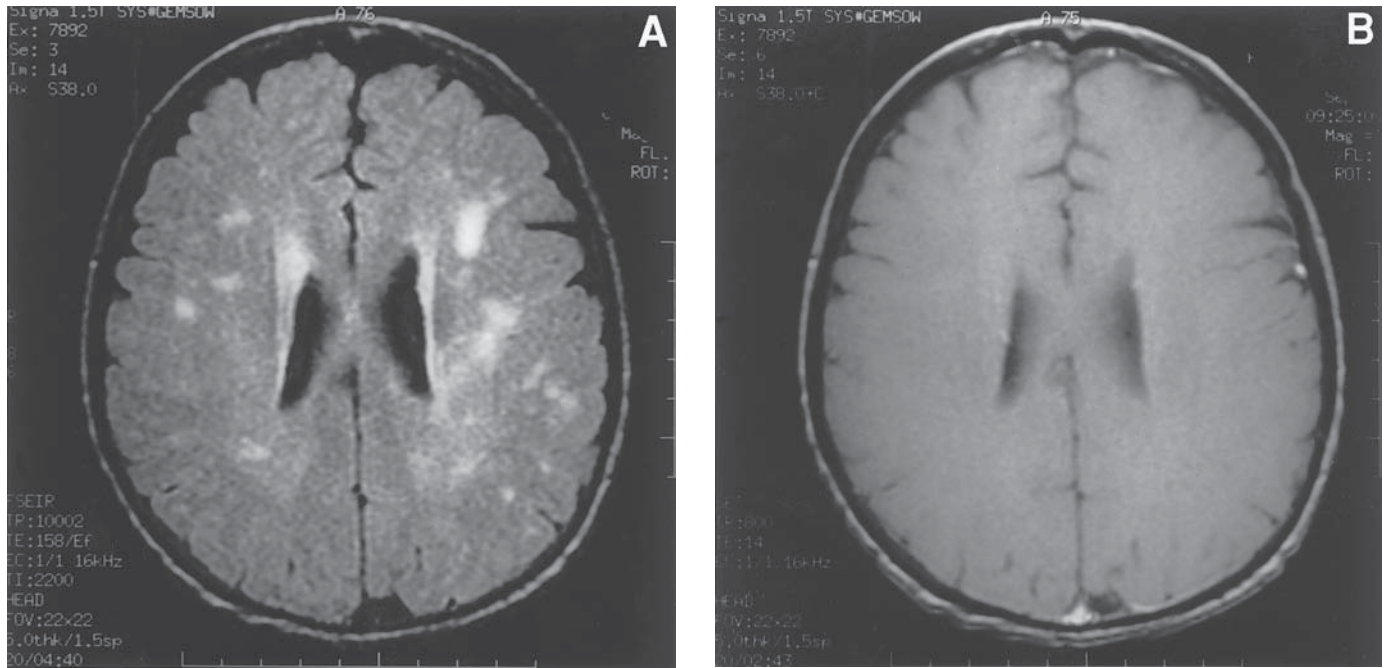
Nonspecific multiple small high-intensity lesions (FLAIR images, A), nonenhancing (T1-weighted, with gadolinium, B) compatible with ischemic small vessel disease on a MRI scan in a 51 yr-old female 5 mo after allogeneic bone marrow transplant for recurrent NHL. She also had a 4 yr history of hypertension. She had developed chronic GVHD. Rapidly progressive coma (<48 h) set in, with respiratory alkalosis. Serum ammonia level was 451 mmol/L, liver enzymes were only mildly elevated, liver biopsy was normal. Treatment with lactulose resulted in decreased ammonia level (61 mmol/L) and improved neurological status. Within 1 wk, however, her ammonia level was again up to 376 mmol/L. Generalized seizures developed, and she expired in spite of treatment with phenylacetate/benzoate.
